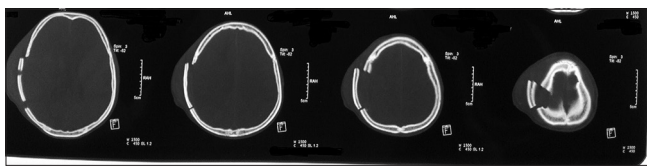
Noncontrast Computed Tomography brain bone window showing elevated right parietal bone fracture
